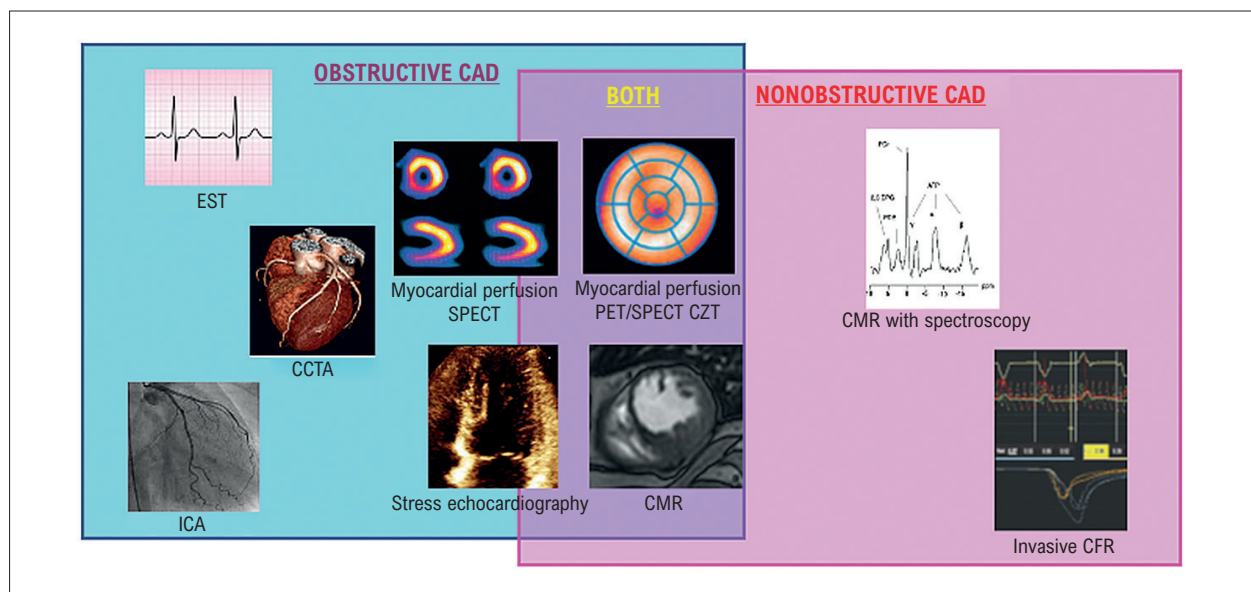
Modalities for the assessment of obstructive and nonobstructive coronary artery disease. CAD: coronary artery disease; CCTA: coronary computed tomography angiography; CFR: coronary flow reserve; CMR: cardiovascular magnetic resonance; CZT: cadmium, zinc, and tellurium; EST: exercise stress test; ICA: invasive coronary angiography; PET: positron emission tomography; SPECT: single-photon emission computed tomography. Adapted from Koilpillai et al.¹⁰⁰
